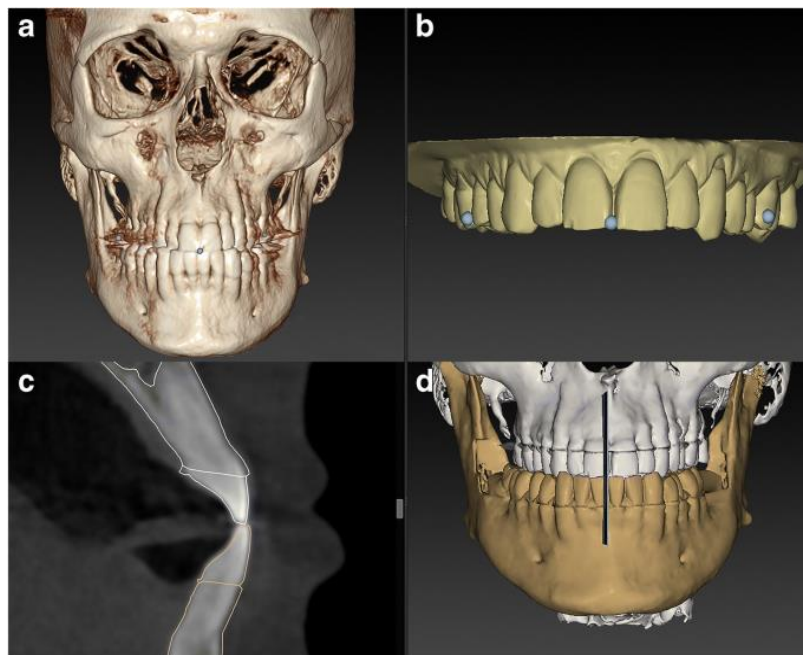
Matching of the intraoral scan with the CBCT scan. The CBCT scan has three dental landmarks. b The intra-oral scan with the same dental landmarks as in the CBCT. c Cross-section of the result of the fusion. d Final result showing the fusion of the intraoral scan with the CBCT. [Adapted from (17)]
